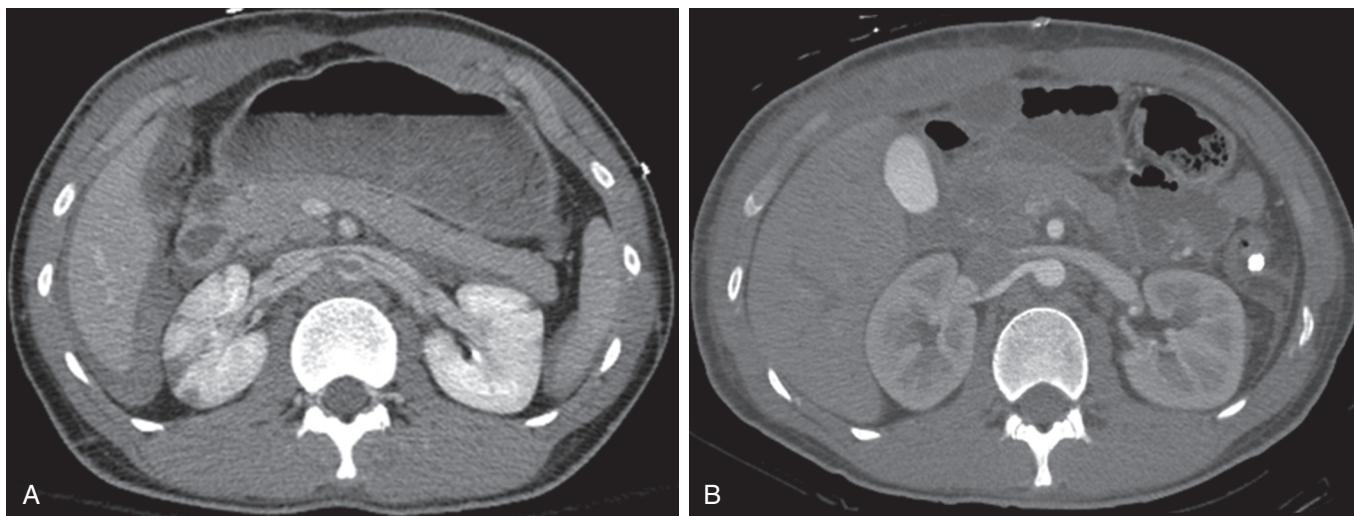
Renal Artery Dissection and Infarcts Associated with Blunt Traumatic Injury. Renal artery dissection associated with aortic dissection and multiple right renal infarcts visible on contrast computed tomography at the time of initial presentation (A). Follow-up scan 1 month later, after initial management with observation and anticoagulation, demonstrates healed dissection without residual perfusion defects (B).
